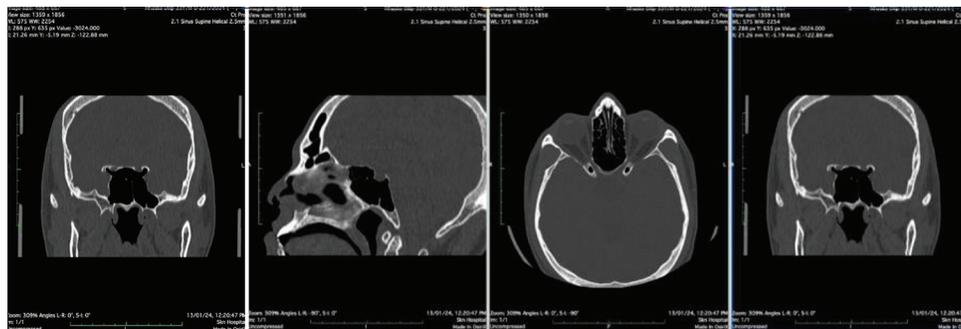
Bilateral pneumatization of the anterior clinoid process in the coronal plane on CT
